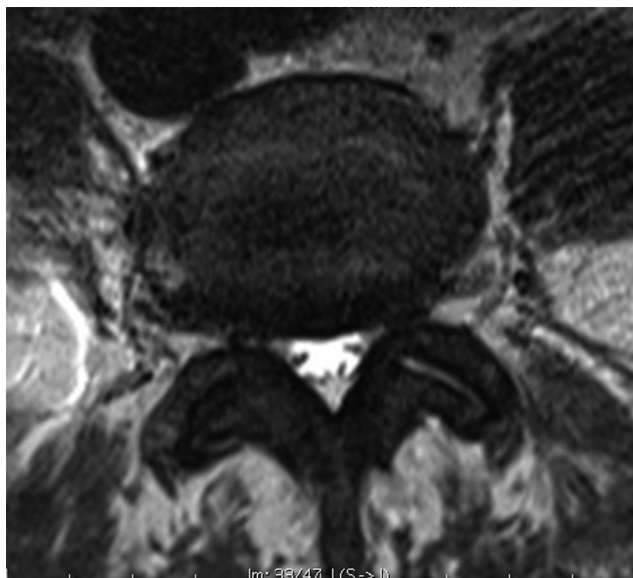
Axial T2 MRI image at L4–L5 level with dural sac surface area measuring 66 mm<sup>2</sup>, but of grade A morphology without rootlet impingement within the dural sac.
